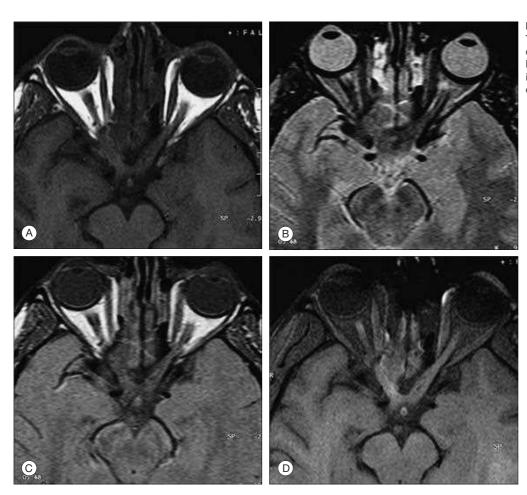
Comparison of Image Contrast. (A) T1-weighted image. (B) T2-weighted image. (C) Protondensity image. (D) Fat suppression reducing the normal bright signal of orbital fat in T1-weighted images and improving contrast between fat, optic nerve, and extraocular muscles. (Courtesy Dr. Ramon Figueroa.)
